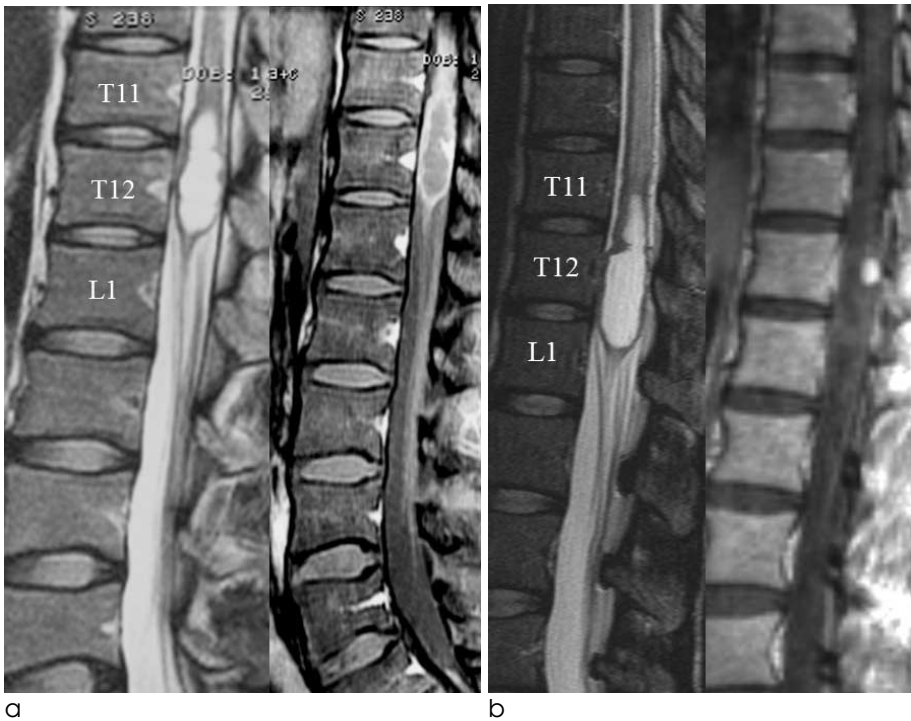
Ventriculus terminalis (a) versus Intramedullary hemangioblastoma (b). a. T2-weighted sagittal image (left) shows cystic mass in the conus medullaris without hydrosyrinx and cord edema. Contrast enhanced T1-weighted sagittal image (right) shows peripheral rim enhancement of the cyst with internal septum. b. T2-weighted sagittal image (left) shows cystic mass of the conus medullaris with extensive cord edema and dilated perimedullary vein. Contrast enhanced T1-weighted sagittal image (right) shows eccentric enhancement of the nodular component within the intratumoral cyst.
